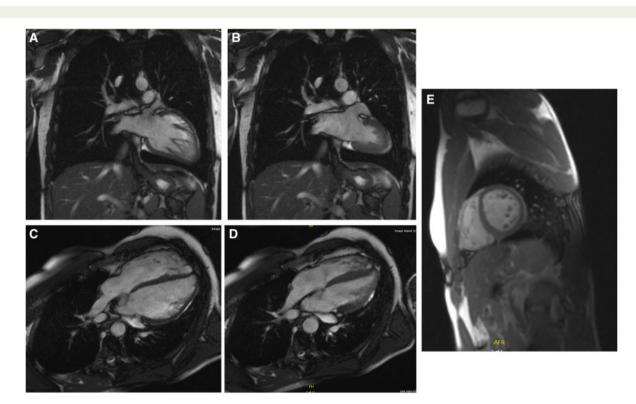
(A) Pre-operative cardiac magnetic resonance imaging coronal cine diastole. (B) Pre-operative cardiac magnetic resonance imaging coronal cine systole. (C) Pre-operative cardiac magnetic resonance imaging cine four chamber view diastole. (D) Pre-operative cardiac magnetic resonance imaging cine four chamber view systole. (E) Pre-operative cardiac magnetic resonance imaging sagittal trufi short-axis view.
